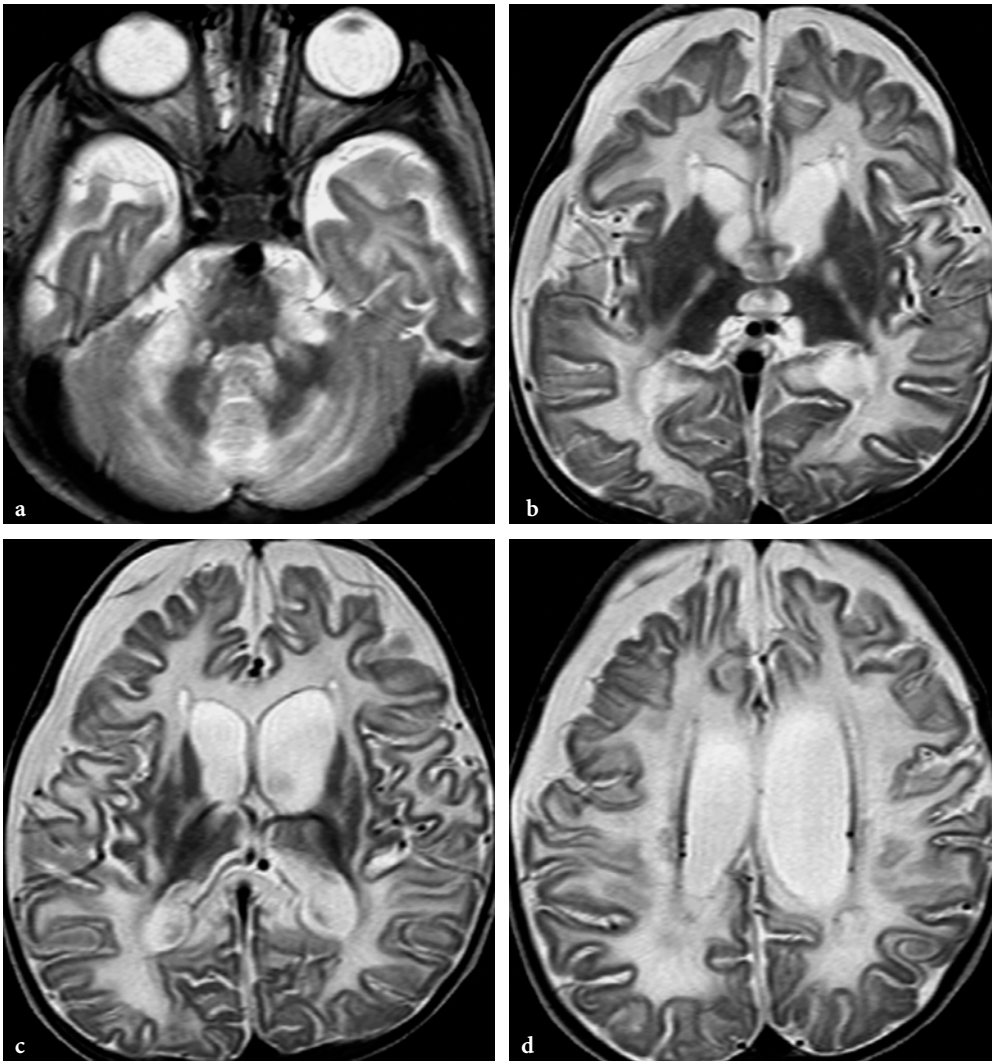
MR imaging findings in an 8-month-old male patient with globoid cell leukodystrophy (Krabbe disease). Clinically, the disease started at the age of 4 months with spasticity. By the time of the MRI study, the patient was in terminal stage, requiring assisted ventilation. a–d Axial T2-weighted fast spin-echo images. The brain is diffusely atrophic. Most cerebral white matter is abnormal; exceptions are the deep cerebellar white matter structures (around and within the hili of the dentate nuclei), brainstem tracts (except for the pyramidal tracts), and the anterior limbs of internal capsules. Note the markedly hypointense appearance of the deep gray matter structures of the cerebral hemispheres
